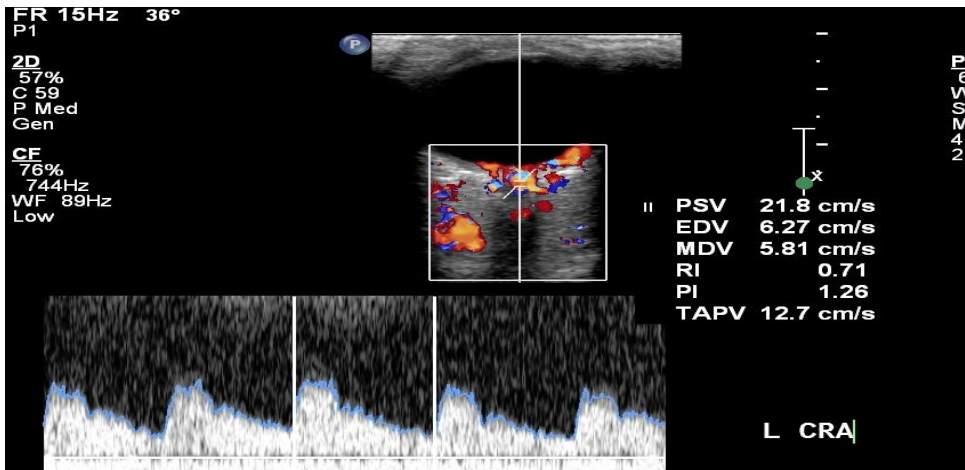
Colour Doppler Image of a patient of POAG showing (A) the vessels and (B) the corresponding spectral waveforms for the central retinal artery (CRA)
